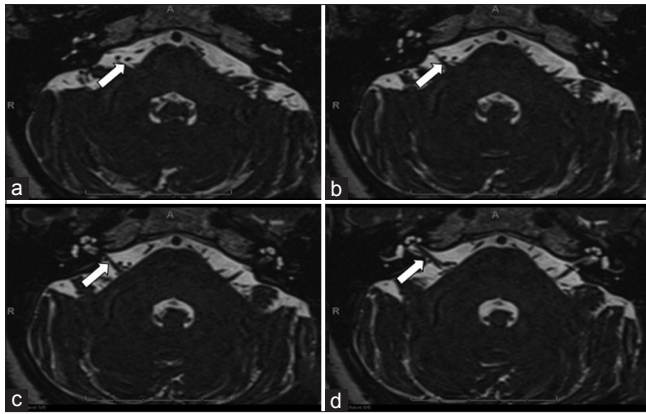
(a-c) Axial MRI thin-section 3D CISS images: the right PICA makes a loop in the cerebello-pontine cistern.(d) Close contact of the PICA and VII nerve. The arrow indicates the close contact between the vessel and the VII-VIII nerve complex
